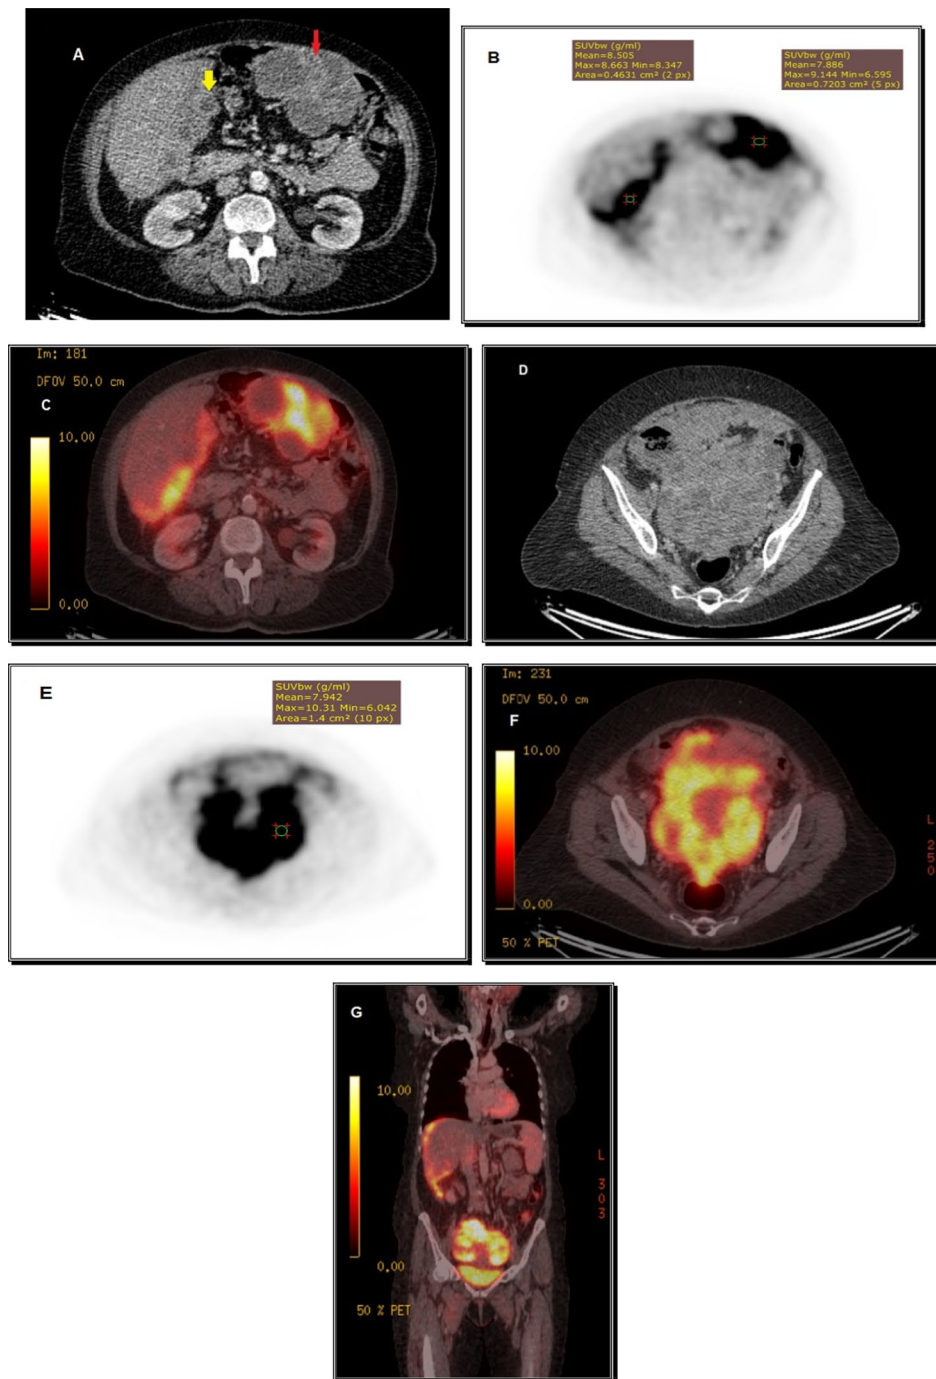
A 65-year-old female patient with a history of ovarian cancer pathologically proven ovarian mucinous cystadenocarcinoma, referred for whole body survey A Axial contrast-enhanced CT. B Axial PET slice at the same level. C Corresponding axial fused PET/CT image, showing Intense metabolically active multiple hypodense peritoneal nodules creeping along and indenting the inferior and lateral serosal surfaces of the liver, the largest is resting upon the gall bladder fossa (yellow arrow) in addition to left hypochondrial enhancing soft tissue mass lesion showing areas of internal breaking down underneath anterior abdominal wall inseparable from bowel serosa (red arrow), both eliciting SUV max ~8.6 and 9.1, respectively. D Axial contrast-enhanced CT. E Axial PET slice at the same level. F Corresponding axial fused PET/CT image, showing bilateral adnexal heterogeneously enhancing large solid mass lesions with areas of breaking down, almost totally occupying the pelvic cavity with significant mass effect upon the surroundings, inseparable from the uterus, posteriorly infiltrating the recto-sigmoid colon and upper rectum and resting upon the urinary bladder, eliciting SUVmax = ~10. G Coronal PET/CT image demonstrating intense FDG diffuse liver surfaces uptake in addition to the pelvic soft tissue mass lesion seen resting upon the urinary bladder
